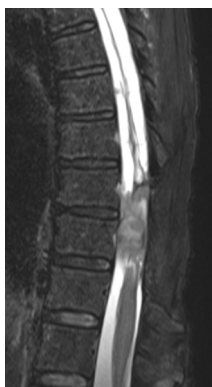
Sagittal T2W MRI shows an intradural extramedullary lesion at T9-T10 level.
